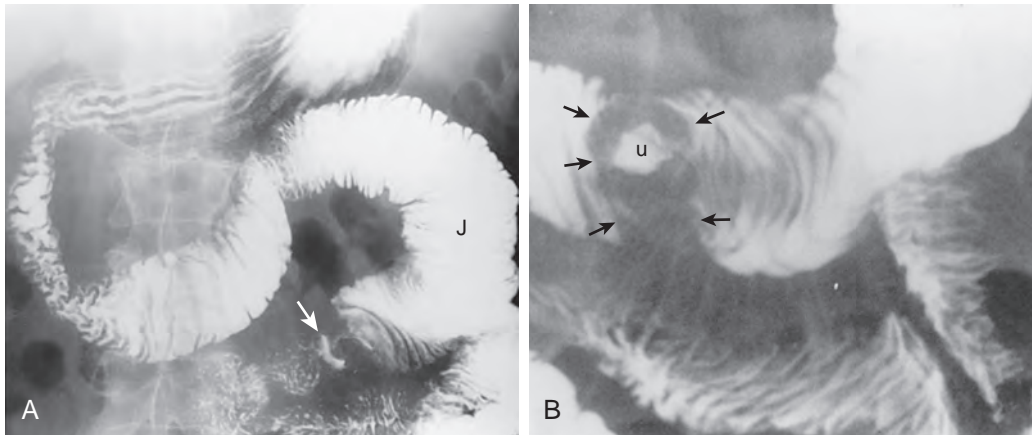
Adenocarcinoma of jejunum causing partial small bowel obstruction. A. Overhead image from an upper GI series shows a dilated distal duodenum and jejunum (J) proximal to a 3-cm focally ulcerated lesion (arrow). B. Spot radiograph shows a circumferential mass (black arrows) with central ulceration (u). This case is an example of how an upper GI series can be converted to a small bowel study when the distal duodenum is dilated.
